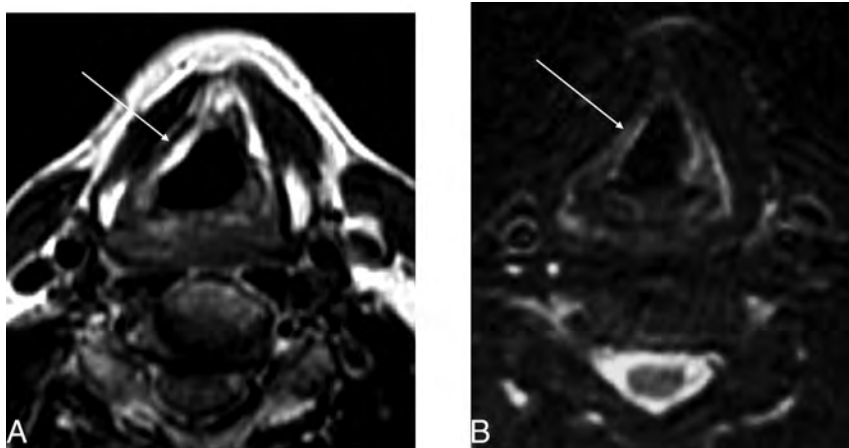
Micronized collagen (Cymetra) approximately 11 months after injection. A, Unenhanced T1-weighted image at the level of the true vocal folds demonstrates T1 hyperintensity within the right vocal fold (arrow; due to volume averaging, portions of the false cord are also partially seen). B, T2-weighted image demonstrates a hyperintense region in the true vocal fold on the right corresponding to the site of injection (arrow).
